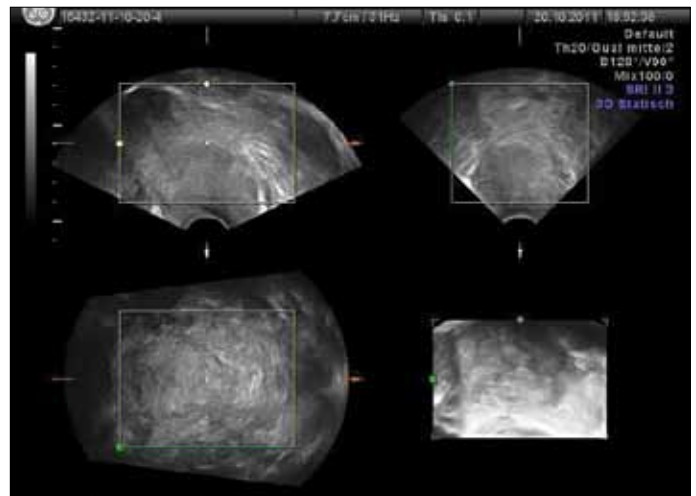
Three-dimensional sonography of barrel shaped cervical cancer in multiplanar sections
